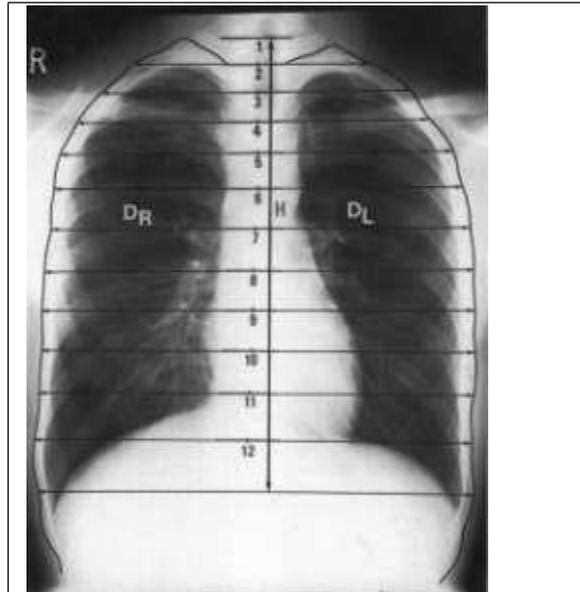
Method of calculating segmental TRs on RC radiographs. DR and DL are distances from the middle of an end- plate to the outlines of the RC, H= the distance from T1-12, [from Grivas et al 15].
